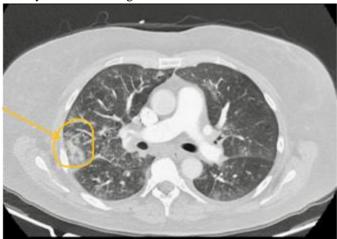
Representative HRCT images. Arrows indicate peribronchial consolidations and masses. The perilobular "arcade-like" pattern is most clearly visible in (right lung).
